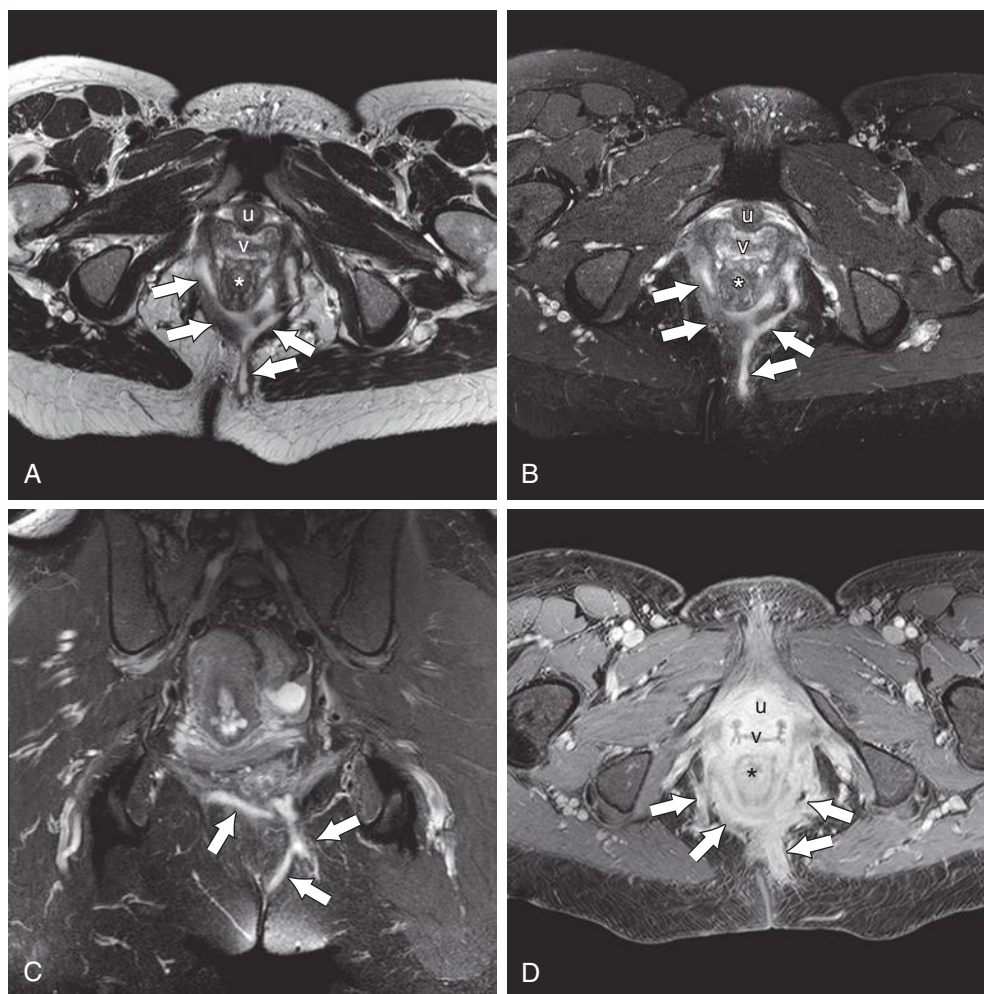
Perianal fistula on magnetic resonance image. Axial T2-weighted images without (A) and with (B) fat saturation show a complex fistulous tract (arrows) partially encircling the internal anal sphincter (asterisk) (on T2-weighted sequences, fluid appears bright). The fistula tracks posteriorly, which may be difficult for ultrasound imaging to characterize. Coronal series (C) shows the cranial extent of the inflammation, which may also be difficult to detect by ultrasound imaging. On postcontrast T1-weighted series (D), there is bright enhancement of the inflammatory tracts without drainable abscess, and the tracts extended to the skin. u, urethra; v, vagina.
